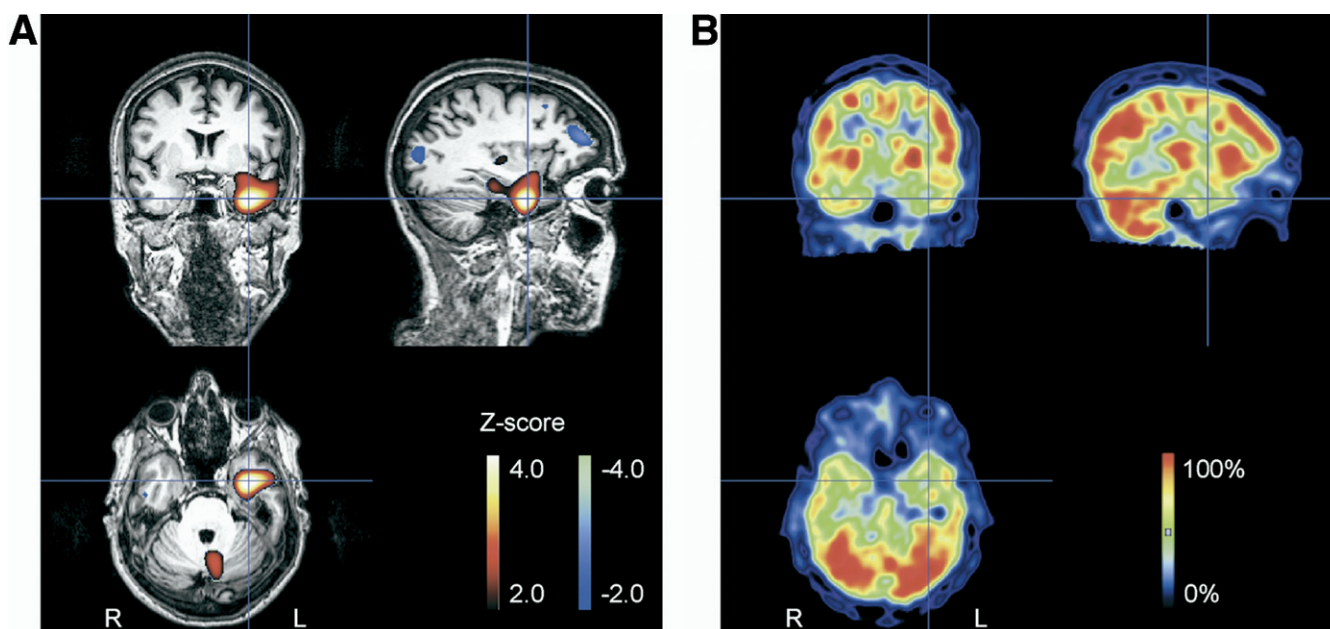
SISCOM (A) and FDG-PET (B) images of a 42-year-old patient with left TLE and normal MRI. SISCOM analysis showed a large cluster of ictal hyperperfusion located at the left temporal lobe (indicated by the blue cross). The ictal SPECT injection was given during a complex partial seizure that lasted 67 seconds, with initiation of the injection 35 seconds after seizure onset. FDG-PET showed a subtle hypometabolism in the same area. All images were coregistered. These functional imaging data were concordant with electroclinical and neuropsychological data, and were considered an important argument to proceed to surgery. Patient underwent a neocortical temporal lobectomy including amygdala, but with sparing of the hippocampus. She has remained seizure free. Neuropathological examination did not reveal an epileptic lesion.
